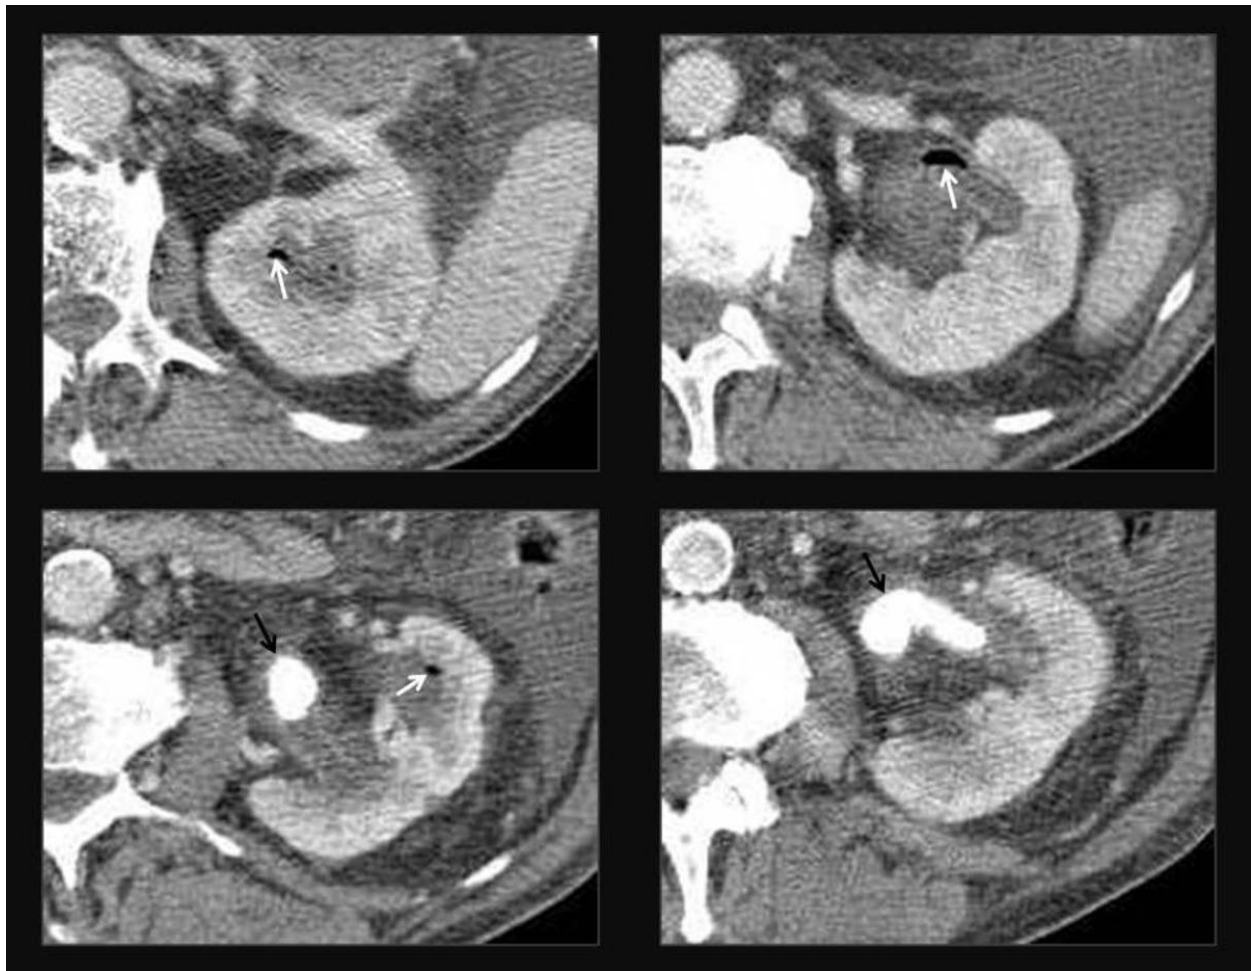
Emphysematous pyelitis. Axial contrast-enhanced CT images show a dilated collecting system with multiple air bubbles (white arrows). Dilatation is caused by a large staghorn-shaped stone (black arrows). There is no evidence of gas collections in the renal parenchyma.
